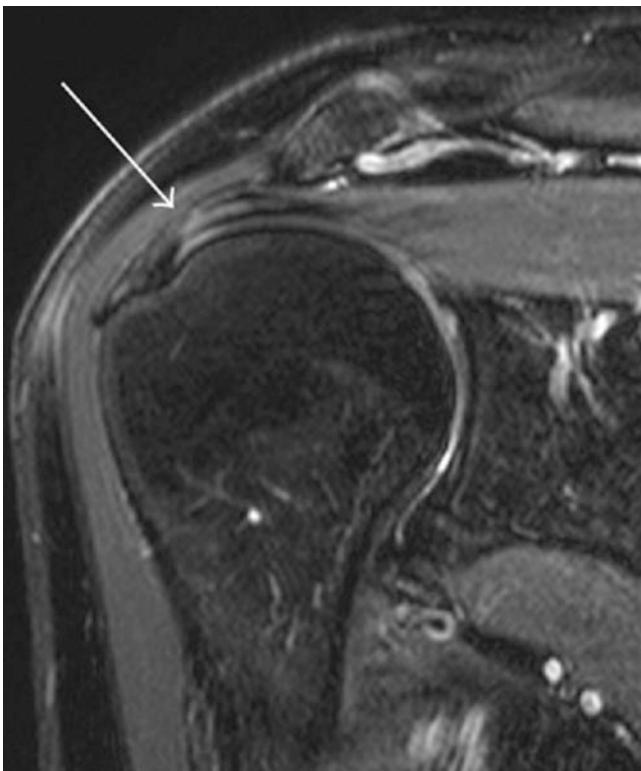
Grade 1 tendinosis on T2-weighted fat-suppressed MRI. (Reproduced from Andrea et al. [64])
